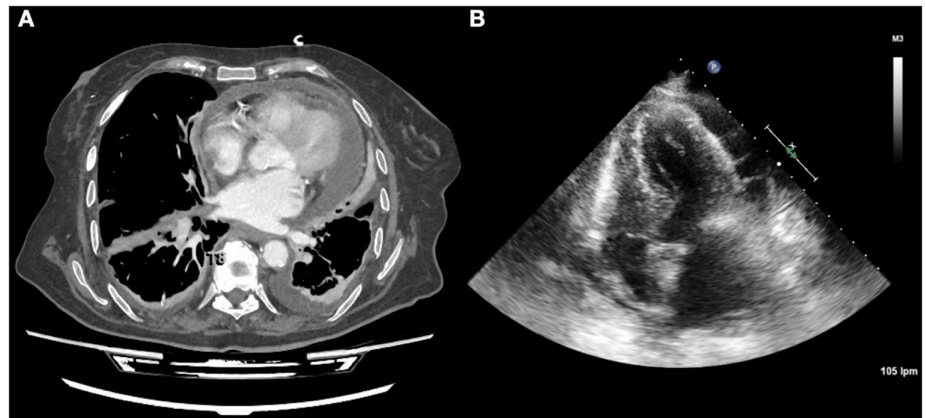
(A) Thoracic CT scan showing a large pericardial effusion, bilateral pleural effusion (more marked on the right side), and areas of atelectasis in the adjacent lung tissue due to compressive effects. (B) Transthoracic echocardiogram in the four-chamber view confirming a fibrinous pericardial effusion, with diastolic collapse of the right atrium indicating tamponade physiology. CT, computed tomography.
